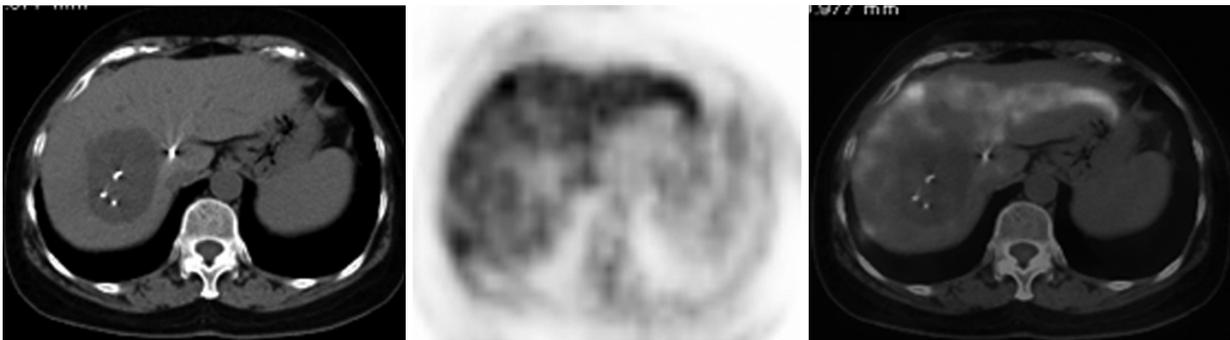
PET/CT imaging showing hepatic metastasis after local therapy in a 60-year-old male postoperative colon cancer patient. ^{125}I seeds brachytherapy was performed in the metastatic lesion of the liver, causing necrosis and ^{18}F -DG uptake decrease of the lesion. However, additional localized hepatic subcapsular hyper-intensive radioactivity was detected, indicating that new liver metastasis had occurred.
